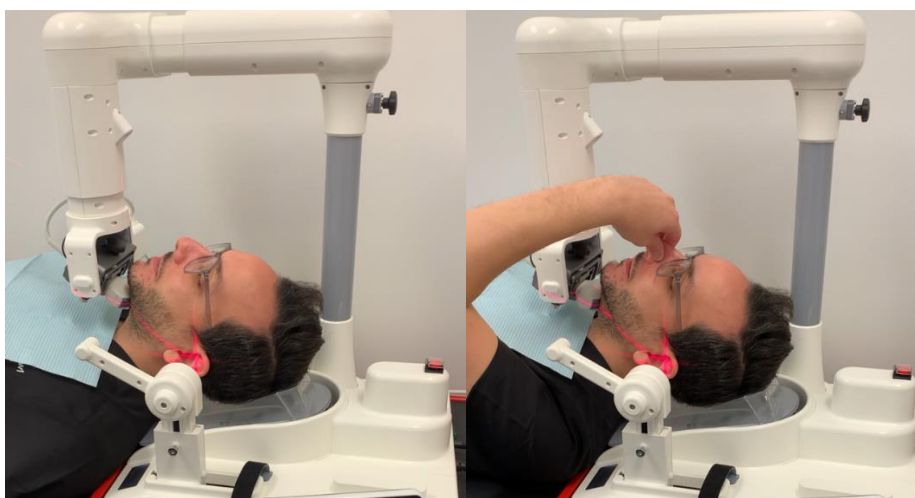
AmCAD-UO taking a normal breathing and a Mueller Maneuver ultrasound volume. Both airway volumes are compared in order to assess the airway collapsibility, and its tone.
